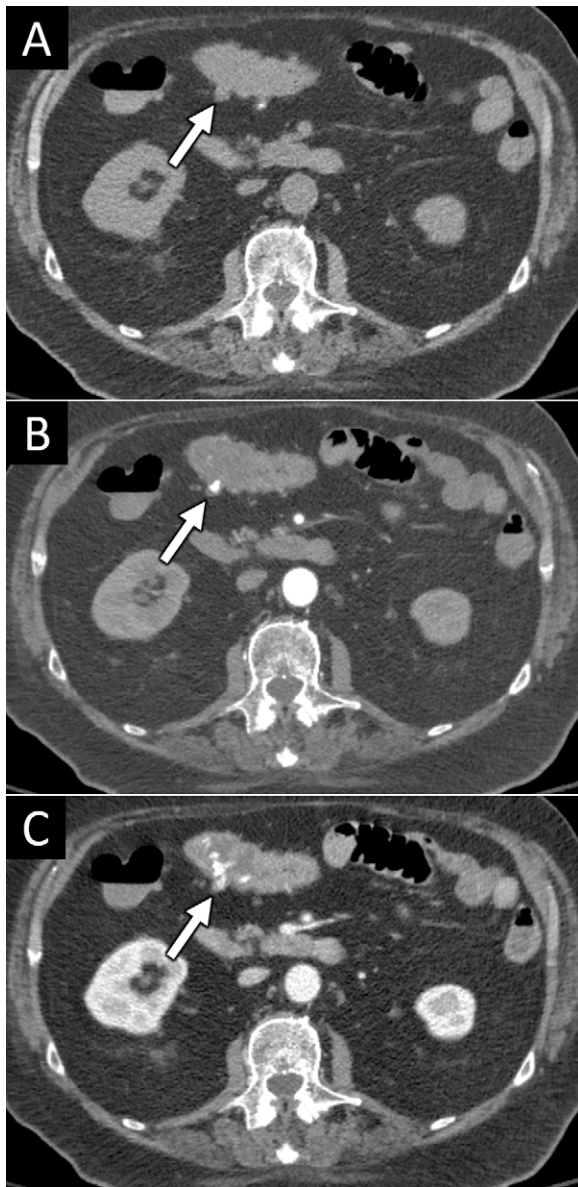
CT angiography (CTA) demonstration of actively bleeding colonic diverticulum in a 78-year-old man with atrial fibrillation taking warfarin with an acute onset of rectal bleeding and dropping hemoglobin level. No clear source of bleeding was identified at recent upper and lower endoscopy. (A) Noncontrast, (B) arterial phase, and (C) portal venous phase CT images show a diverticulum in the transverse colon (arrow in A), with contrast material extravasation in the diverticulum on arterial phase images (arrow in B) that changes in size and density in the portal venous phase (arrow in C) and extends further into the adjacent colon, consistent with active bleeding. Following CTA, catheter angiography was performed, which showed active bleeding from a vasa recta branch of the right colic artery (not shown). This was successfully treated with coil embolization.
